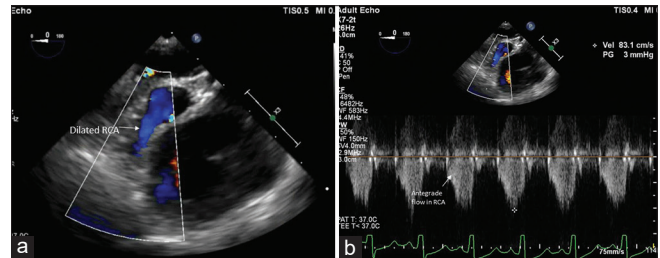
(a and b) Transesophageal echocardiogram still frame shows dilated right coronary artery system with antegrade blood flow during diastole (blue), spectral Doppler imaging to confirm antegrade blood flow in diastole
